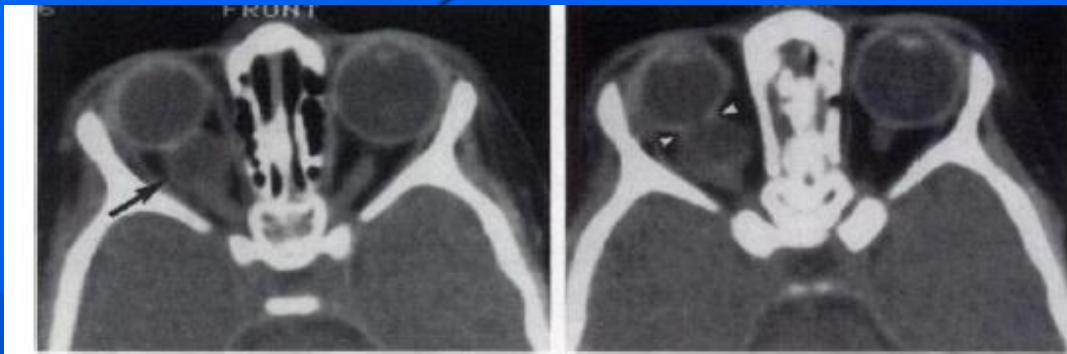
Case 1. (a) CT image (2-mm section, axial view) acquired at the level of the optic nerves demonstrates cystic expansion of the optic nerve (arrow). Right globe is smaller (microphthalmia) than the left. (b) CT image acquired at the level of the junction of the right optic nerve and right globe confirms choroidoscleral defect (arrowheads), associated with microphthalmia.
